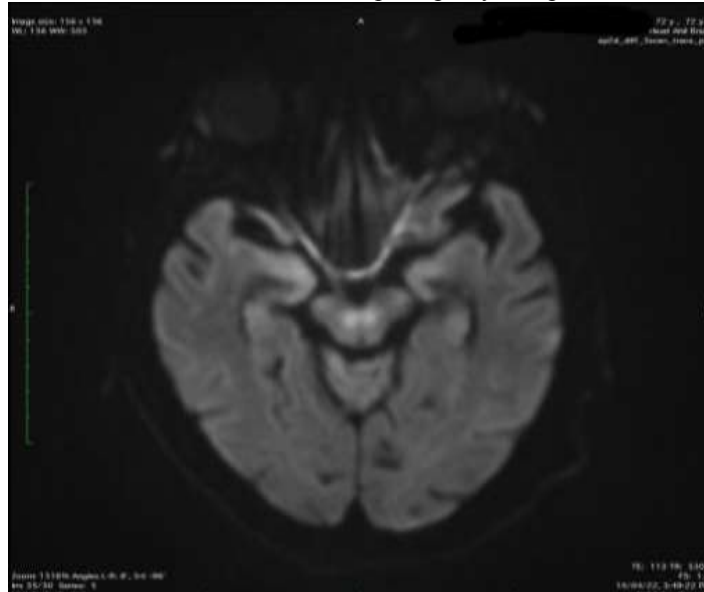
MRI Image Showing the DWI image with hyper intensity in peri ductal region.
